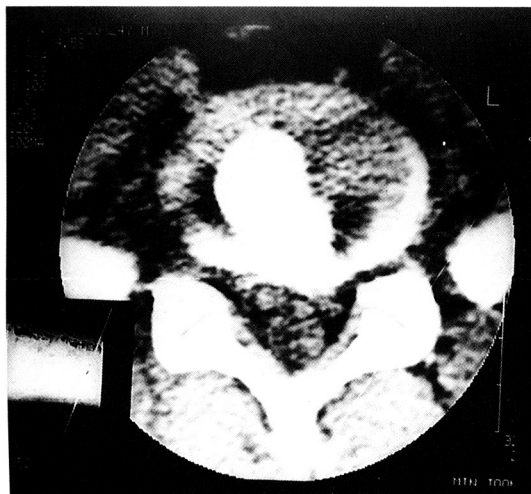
Discographic CT finding of a broad dye base disc protrusion.
